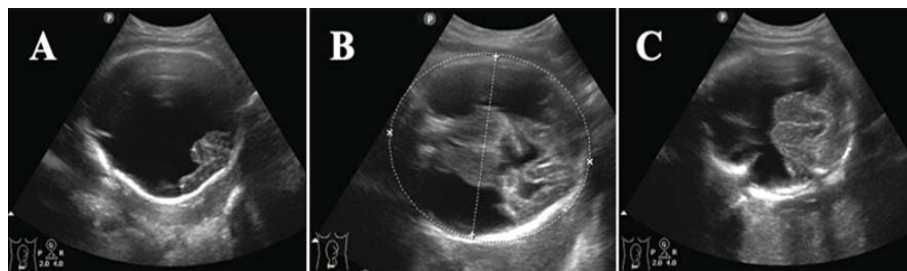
2D Transabdominal Ultrasound of fetal head (Axial View) at 37 weeks' gestation: (A) transventricular plane showing absent of bilateral cerebral cortex with no intact cortical rim and falx cerebri disruption, (B) transthalamic plane showing thalami and midbrain structures were still present, (C) transcerebellar plane showing cerebellum and other posterior fossa structures were still present.
